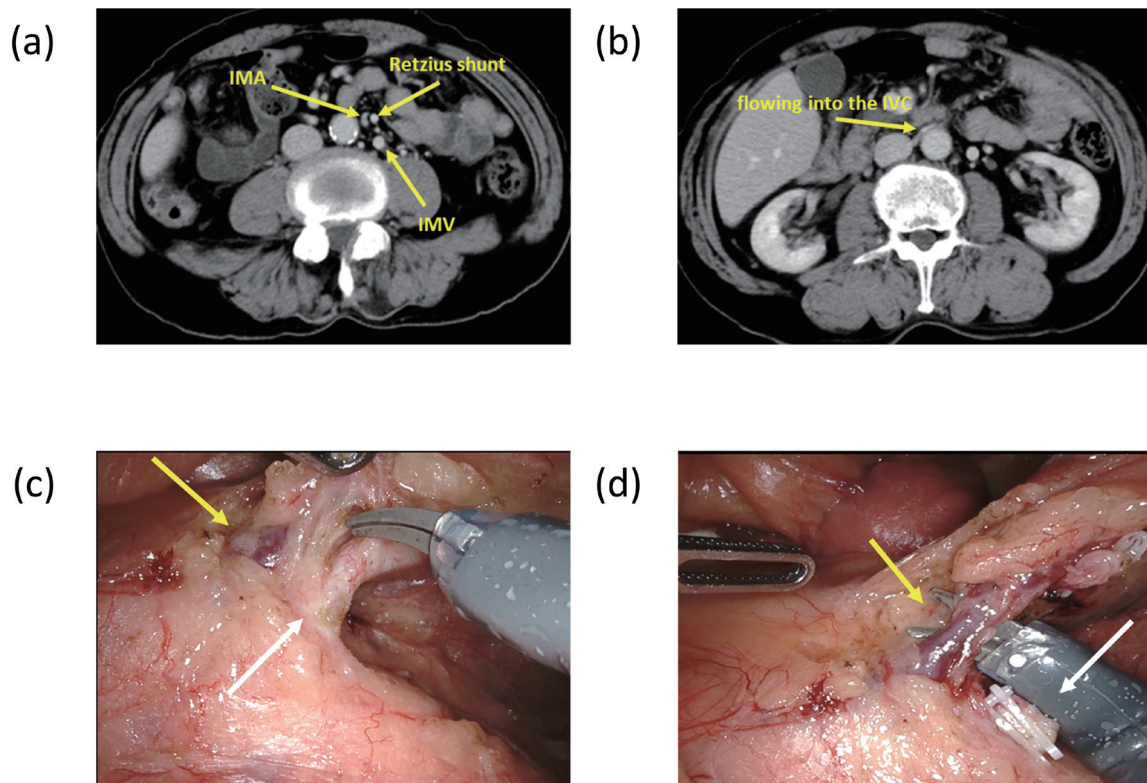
Intraoperative findings. (a, b) Contrast-enhanced CT shows the Retzius shunt crossing the IMA and the IMV flowing into the IVC. (c, d) Intraoperative findings indicate the Retzius shunt (yellow arrow) outside the IMA (white arrow).
